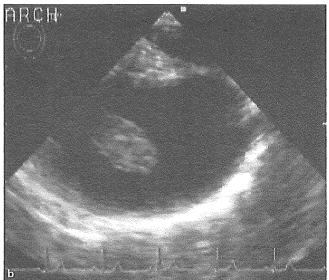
Diagnostic images of patient 1. a Brain diffusion-weighted imaging shows an acute infarcted lesion in the left middle cerebral artery area. b Transesophageal echocardiography reveals a mobile mass and no atherosclerotic lesion in the aortic arch. c Thoracic cine-magnetic resonance imaging reveals a floating mass attached in the aortic arch.
